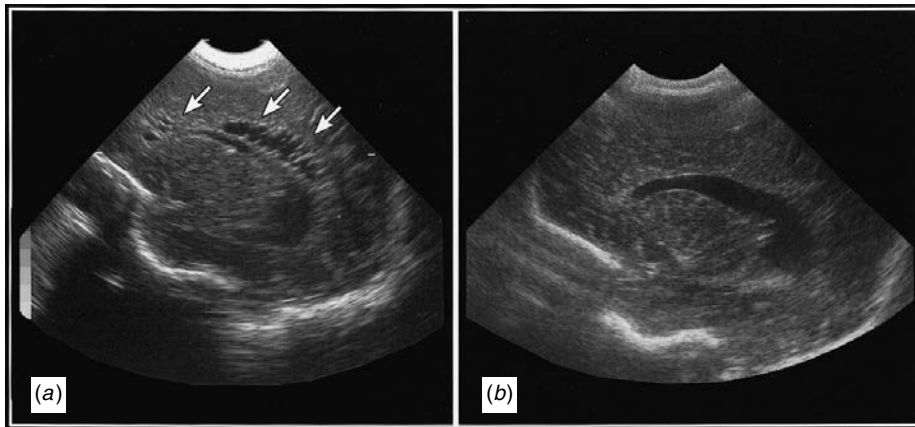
These images show the evolution of cystic PVL on sagittal cranial ultrasound images in a 27 week infant. (a) Hypoechoic areas corresponding to cystic degeneration in periventricular white matter at 2 months of age (white arrows); (b) Resolution of the cysts with compensatory ventriculomegaly at 6 months of age. The findings in Panel A carry a risk for CP which approaches 100%. (These images were previously published in Hoon & Melhem, 2000.)
